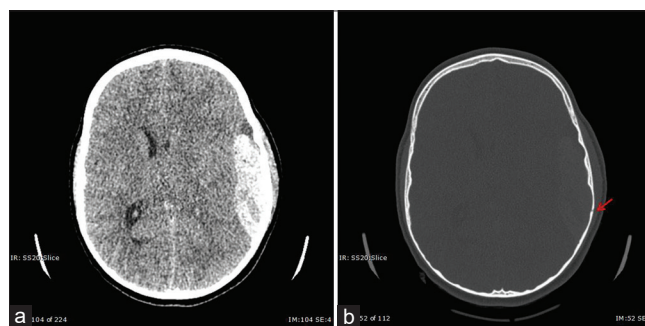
(a) Axial CT head, no IV contrast: Large left epidural hematoma with left to right shift. (b) Axial CT head: Parietal fracture
